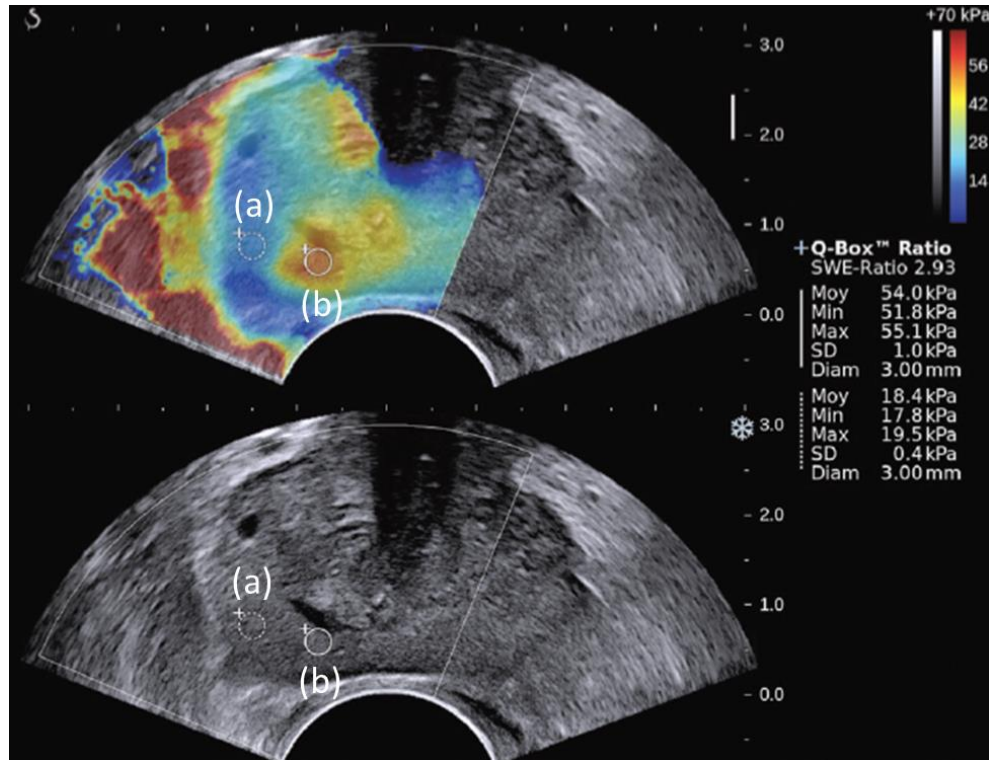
Shear wave elastography (SWE) (top) and B-mode ultrasound (bottom) images of (a) benign area outlined with dashed line, and (b) malignant area outlined with solid line. Adapted from Correas et al. 2015 [70].
